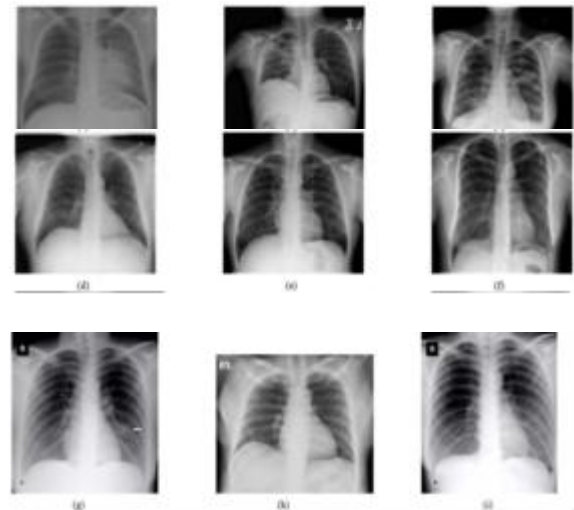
Example of Chest X-Ray images as given in Cohen et. al. first row shows CAP, second row shows the normal and the third row shows the COVID-19 cases
